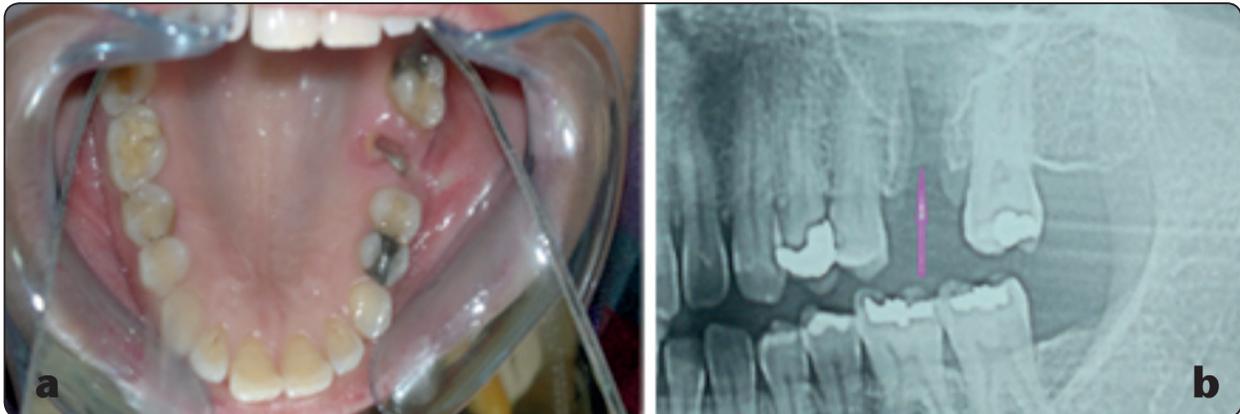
a) OAF, b) Preoperative panoramic X-ray showing OAF (arrow).
